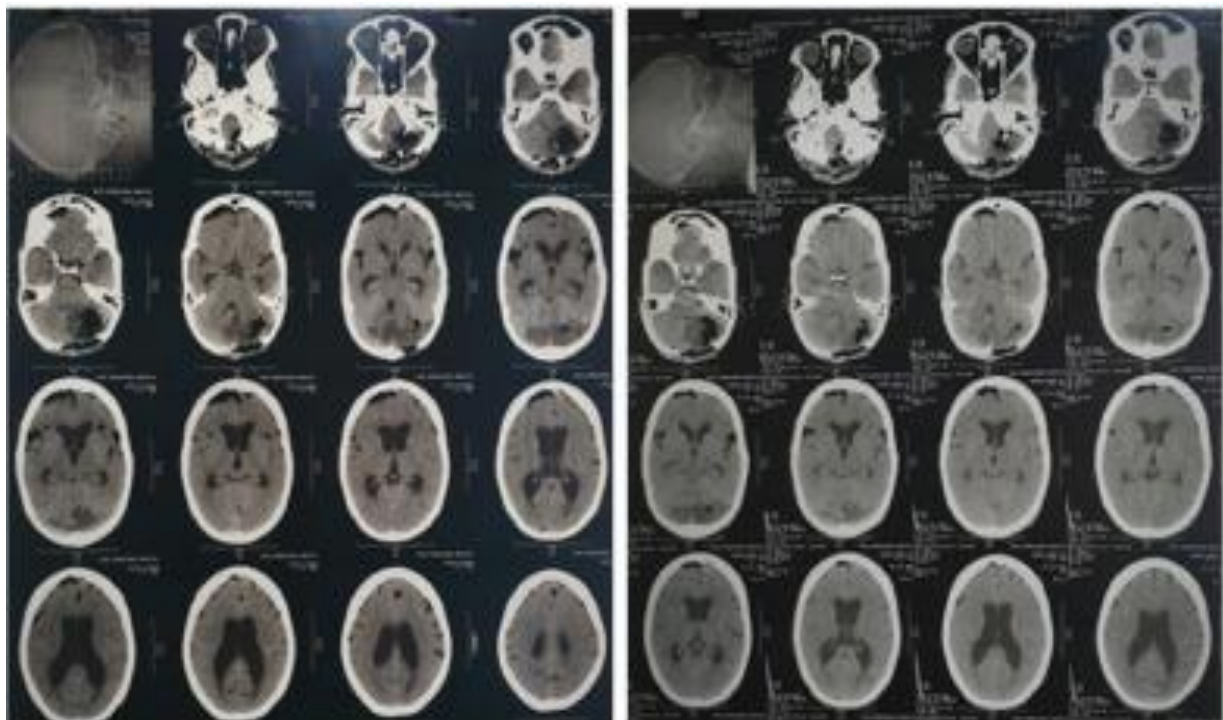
B: Postoperative and 1 month postoperative CT scans of Case 3.
